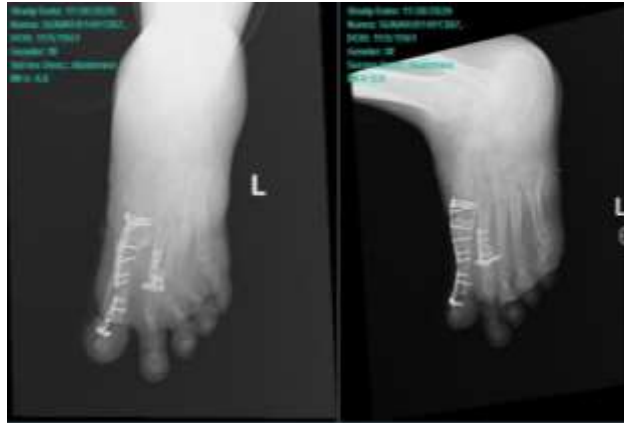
Evaluation X-ray and clinical picture after 3 month operation
